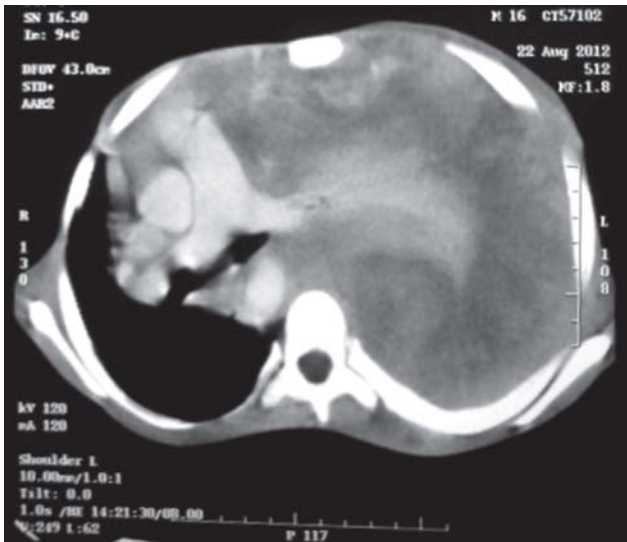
Computed tomography of thorax showing left-sided intra-thoracic mass with mediastinal shift to the right.
